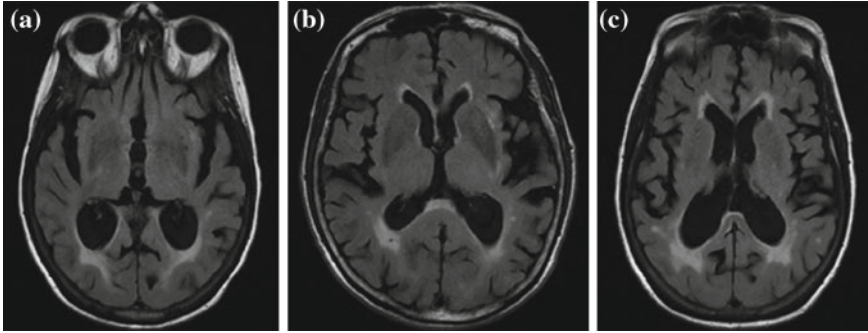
Three examples of FLAIR MRI with WML. a Example 1. b Example 2. c Example 3
